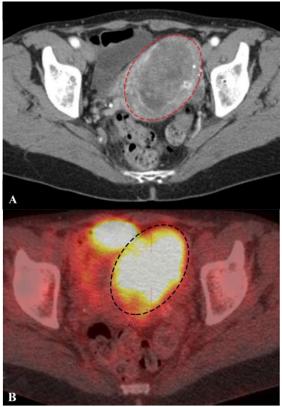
Distinctive quality of preoperative imaging in a 65 years old female with endometrial cancer. A: sagittal CE CT image. B:
